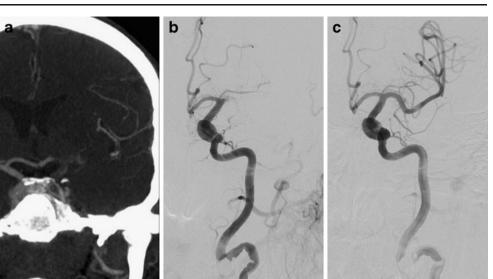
a Coronal reformatted image of CT angiogram at presentation shows a left carotid T-type occlusion. b Control angiogram performed after manual aspiration shows debulking of the thrombus burden from the ACA and terminal ICA. c The MCA was subsequently revascularized to TIMI 3 flow with a Solitaire FR device
